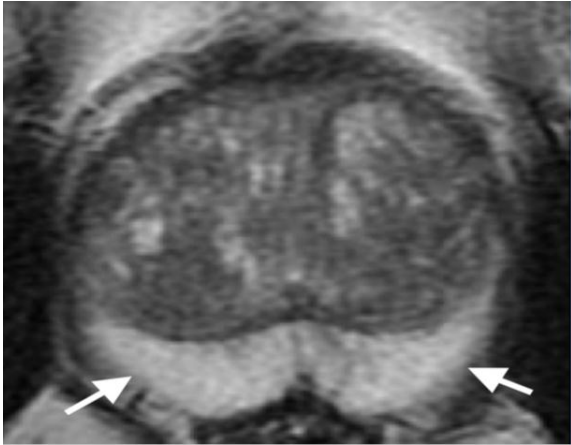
Normal prostate. T2-weighted MR image demonstrates normal prostate parenchyma with hyperintense peripheral zone (white arrow) and low signal central zone (black arrow) [9].
